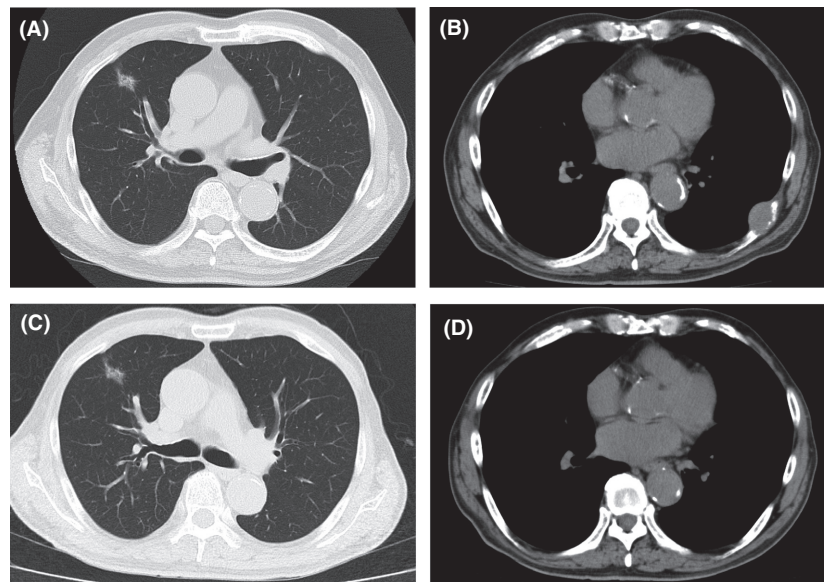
(A–B) Chest CT indicating a 22-mm irregular opacity in the right upper lobe (A) and a 30-mm mass in the rear side area of the left 8th rib (B). (C–D) Chest CT performed 2 years previously indicating the same size lung opacity (C) without the rib lesion (D).
